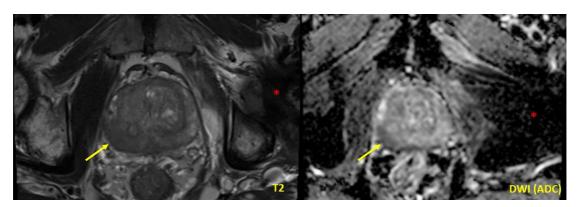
Granulomatous prostatitis mimicking high grade prostate cancer may manifest as a PIRADS 5 lesion on MRI. The arrow denotes a 2.2cm diffuse area of low signal intensity at the right mid peripheral zone that corresponds to restricted diffusion on the ADC map. The star denotes image artefact introduced by a left hip prosthesis. Despite the presence of a prosthesis, the images are diagnostic and can still provide important information for detection and staging.
